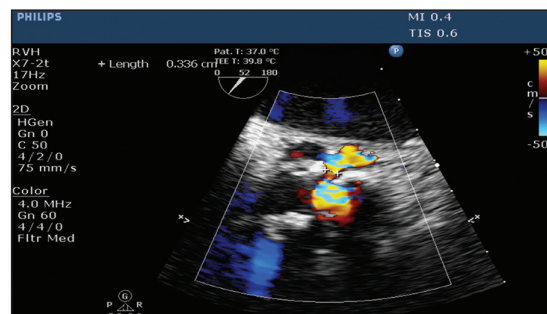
ME AV SAX view with CFD showing colour flow into the cavity. ME SAX = mid esophageal short axis; AV = aortic valve; CFD = colour flow Doppler.
